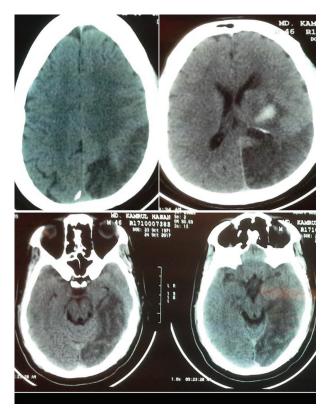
CT scan of head showing haemorrhage in left capsuloganglionic region and large infarction in left parieto-occipito- temporal region.
